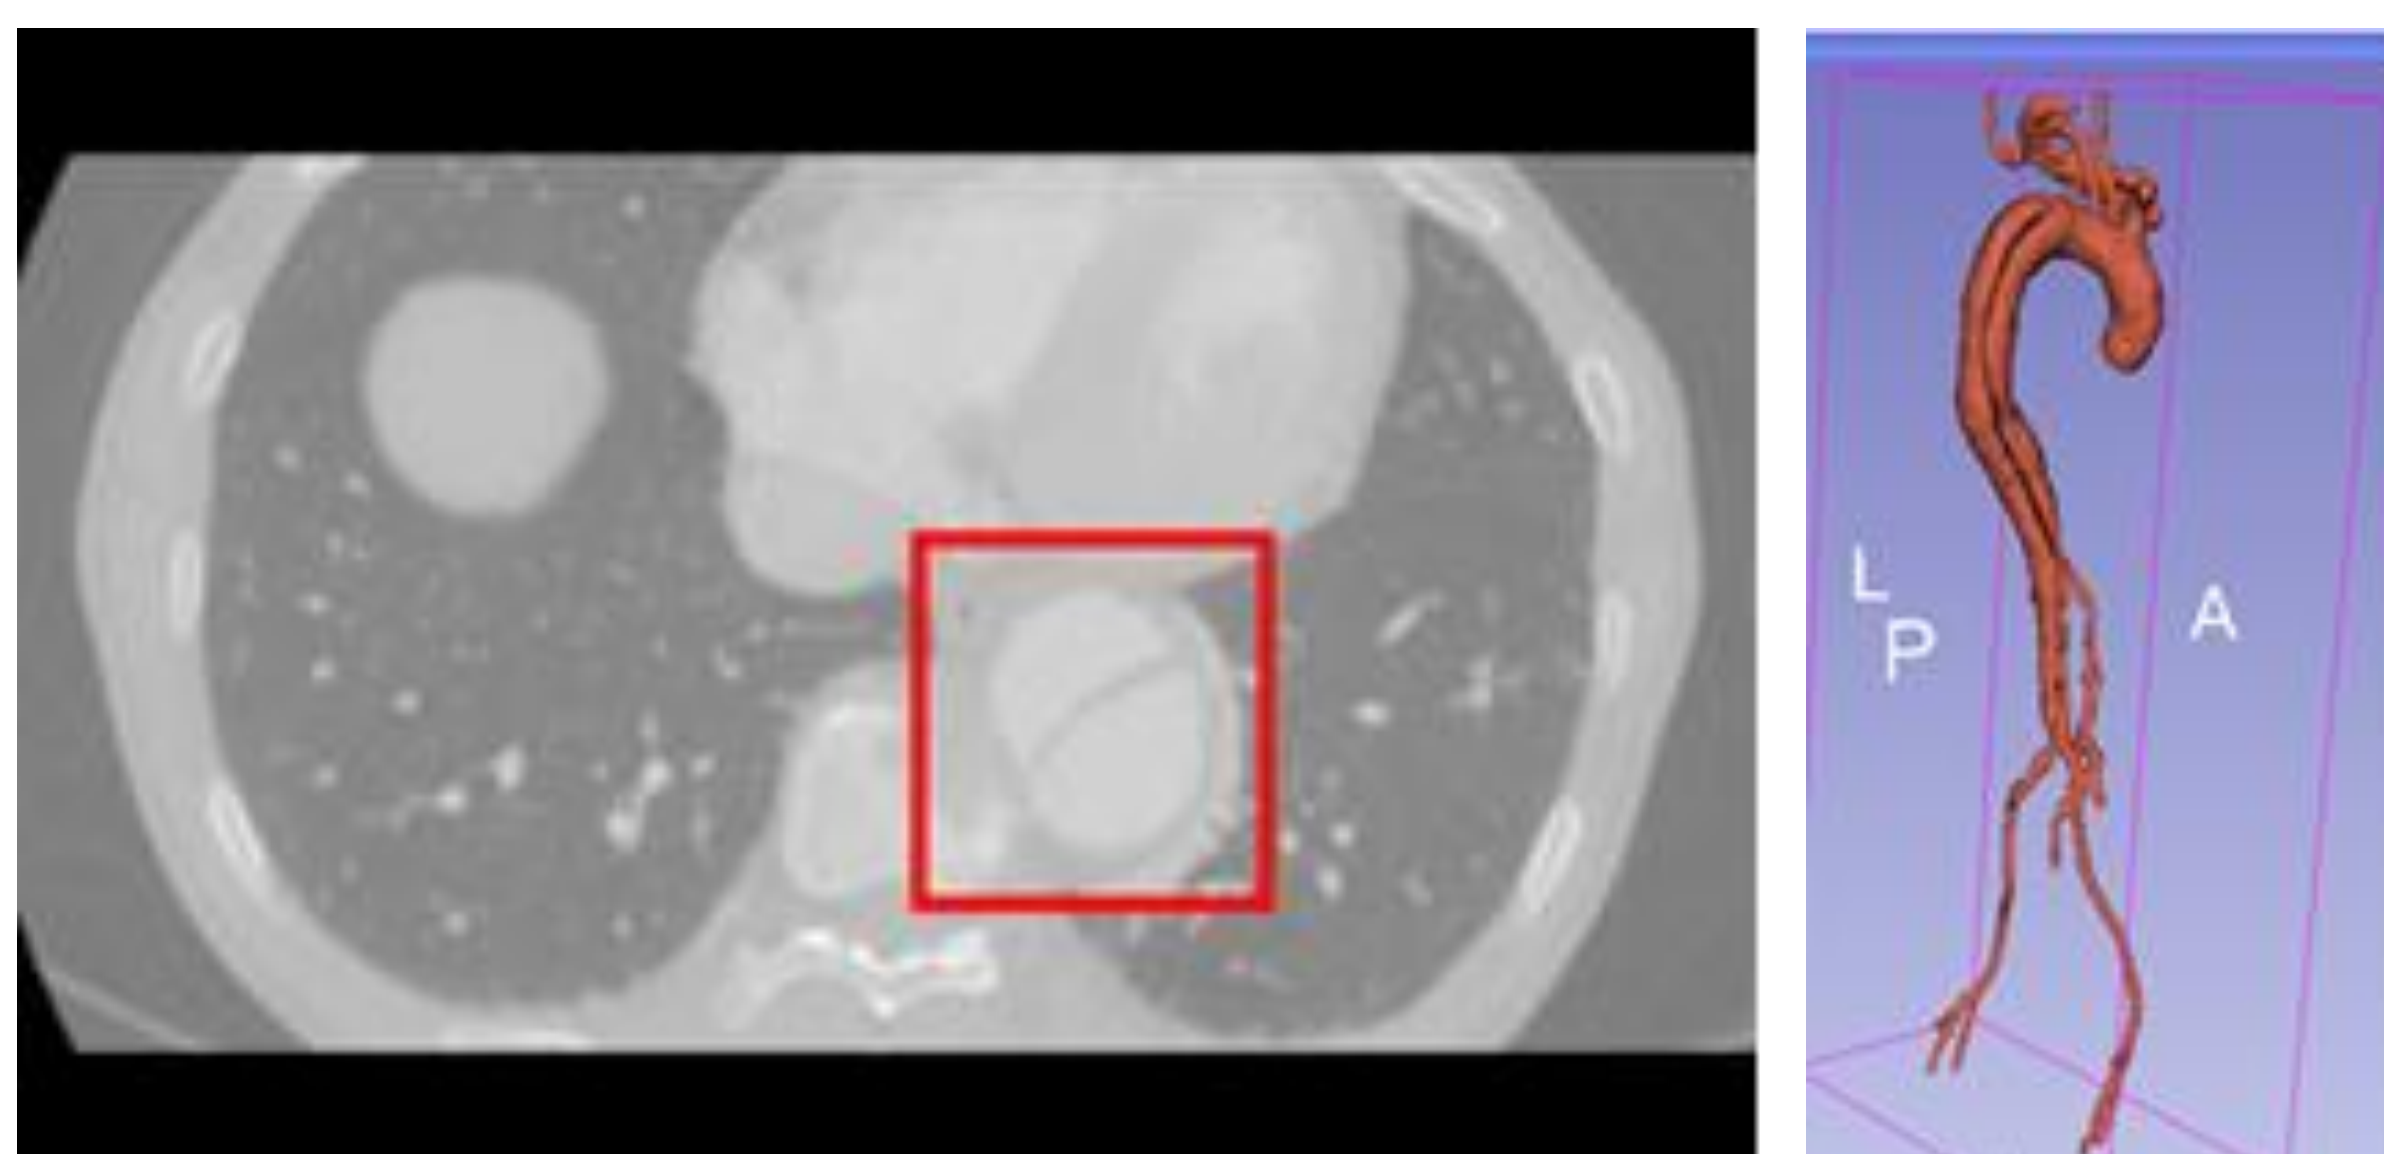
On the left: Example of AD (limited in red) in a CTA scan, the flap is clearly visible. On the right: example of an obtained segmentation.
